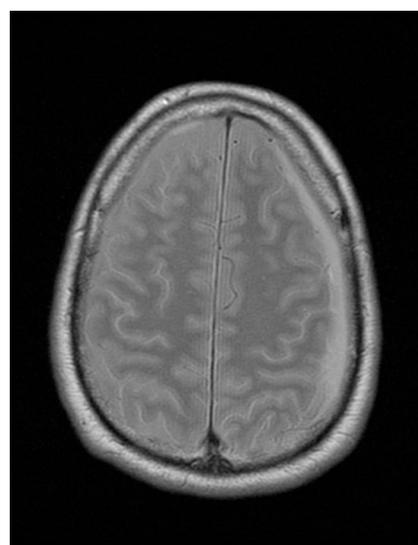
Axial proton diffusion-weighted brain MR image displaying a hyperintense left frontoparietal extra-axial collection with a maximum thickness of 1 cm.
